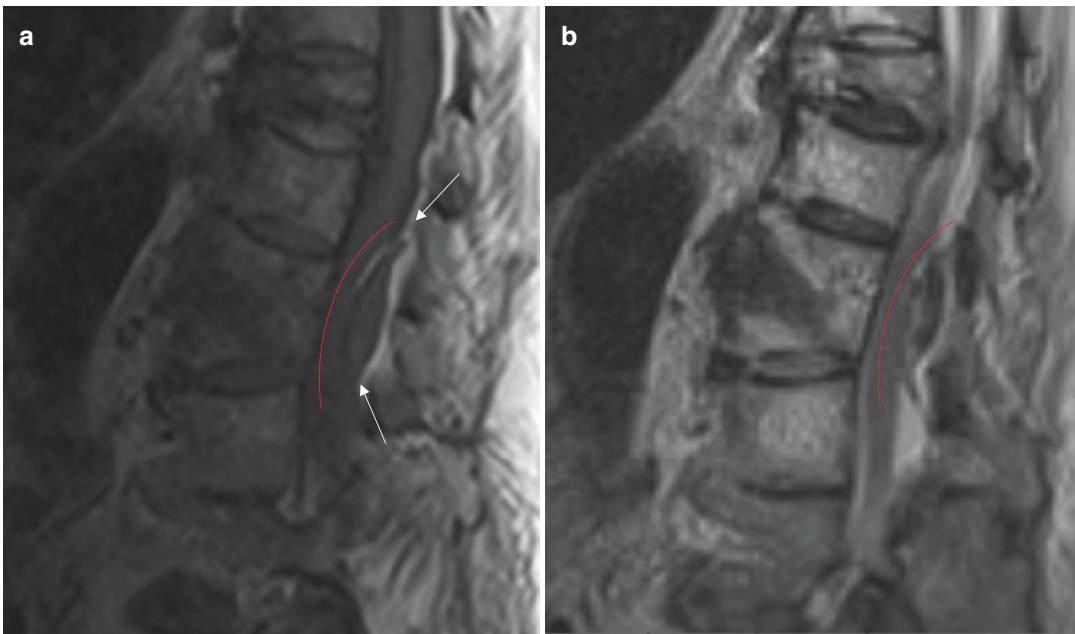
(a) Sagittal T1-weighted image in a patient with multiple fractures demonstrates dorsal epidural fluid collection with evidence of bright epidural fat cap (white
